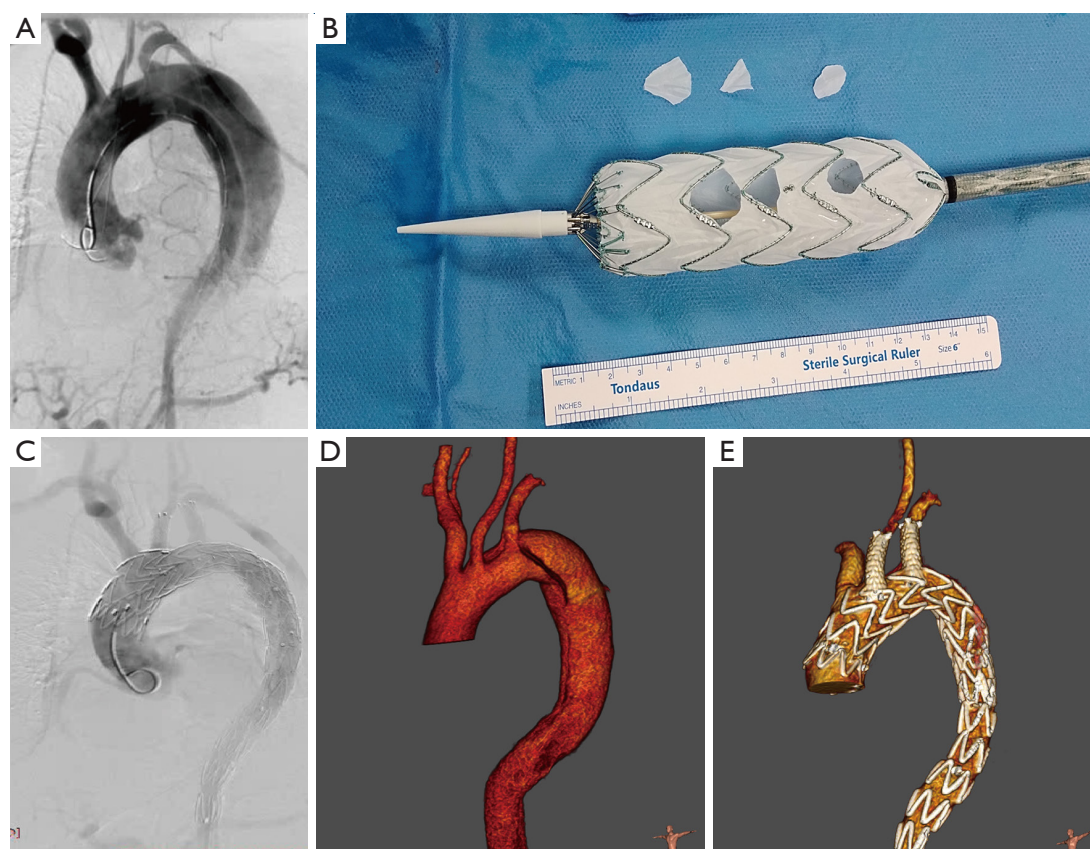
TEVAR with fenestrated surgeon-modified stent-graft (A) DSA before treatment of a type B aortic dissection with (B) a fenestrated surgeon-modified triple stent-graft, and (C) DSA after deployment of the stent graft, showing complete exclusion of the pathologies and patency of the supra-aortic vessels, with bridging stent grafts in the LCCA and LSA. (D) Three-dimensional CTA reconstruction before treatment of an aortic arch dissection with a fenestrated surgeon-modified single stent-graft, and (E) CTA reconstruction after treatment, with bridging stent grafts in the LCCA and LSA. TEVAR, thoracic endovascular aortic repair; DSA, digital subtraction angiography; LCCA, left common carotid artery; LSA, left subclavian artery; CTA, computed tomography angiography.
